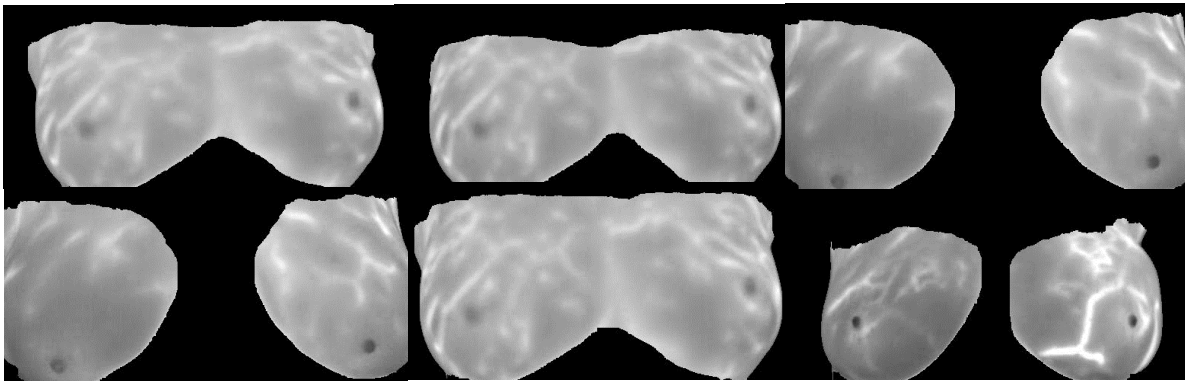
Sample data entries from the Breast Cancer Patients MRI dataset.
